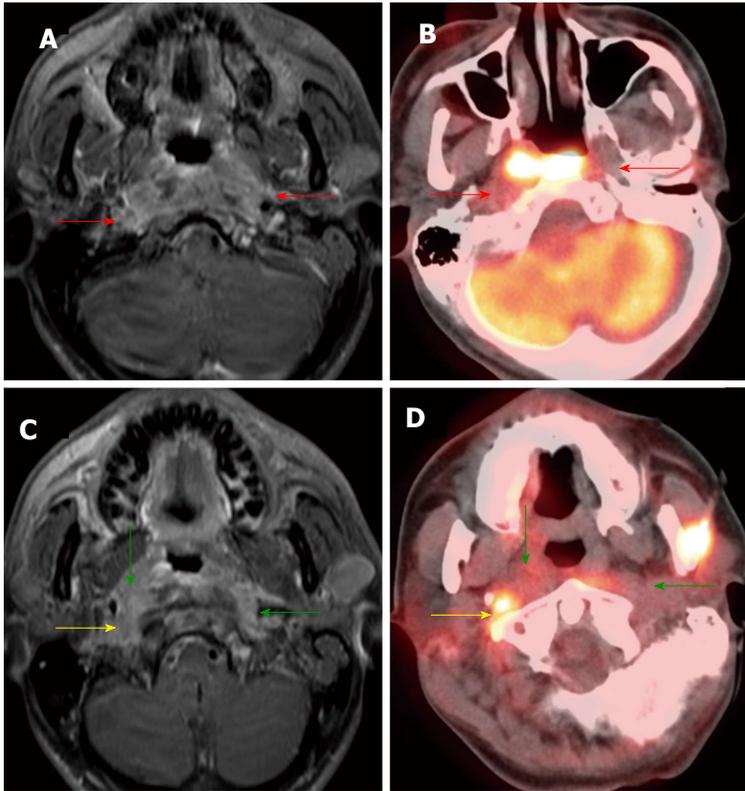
Positron emission tomography/computed tomography underestimates size and extension of the nasopharyngeal carcinoma and retropharyngeal lymph nodes compared to magnetic resonance imaging. The approximate lateral extension (red arrows) of the nasopharyngeal carcinoma is well demarcated on magnetic resonance imaging (MRI) (A). The tumor appears to be smaller on positron emission tomography/computed tomography (CT) (B) as compared to MRI because the lateral portion of the tumor is hypometabolic. Inferior to the primary tumor site, there is metastatic bilateral retropharyngeal lymphadenopathy (yellow and green arrows). The full extent of retropharyngeal lymph node involvement is better assessed by MRI (C) than CT (D). Only the right lateral retropharyngeal node is FDG avid.
